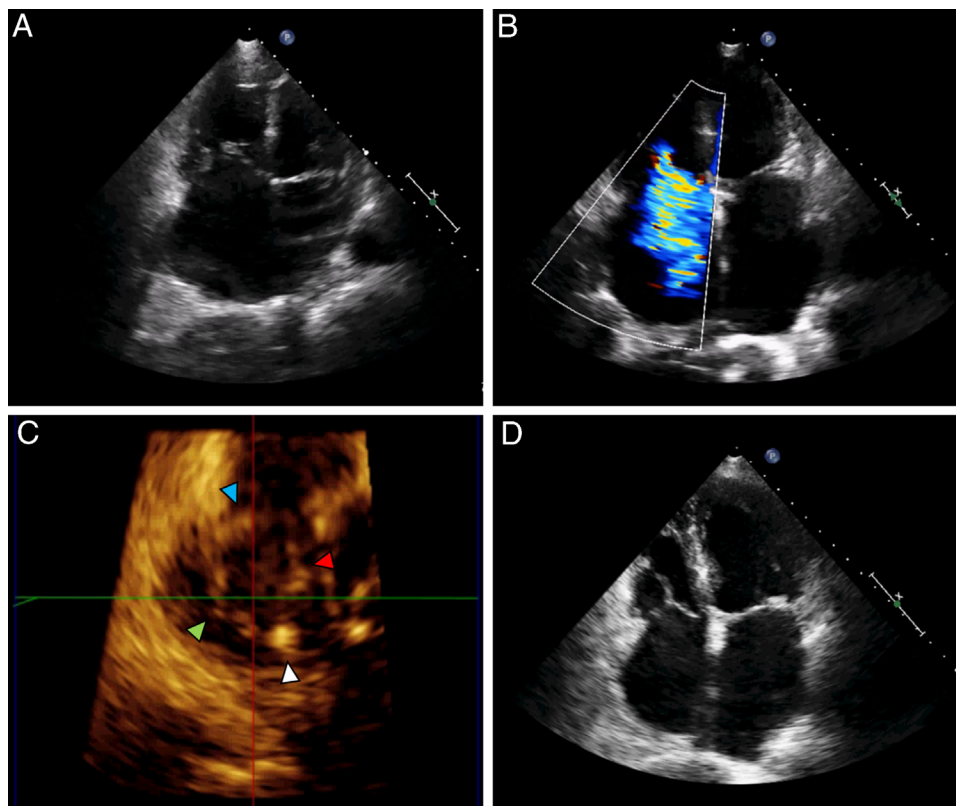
Figure Echocardiographic images. A: Apical 4-chamber view demonstrating poor coaptation of tricuspid valve (TV) leaflets, biatrial enlargement, and right ventricular (RV) dilatation 6 months after pacemaker implantation. B: Doppler signal confirmed severe tricuspid regurgitation (TR), but its etiology could not be determined. C: Three-dimensional echocardiogram showing the pacemaker lead (white arrowhead) lying in the commissure between the posterior (green) and septal (red) TV leaflets. Restriction of septal leaflet systolic excursion was observed and attributed to the lead. The anterior leaflet (blue) is also visible. D: Apical 4-chamber view demonstrating improved TV leaflet coaptation and normalization of RV size 12 months after percutaneous lead extraction. Mild TR was noted (not shown).
